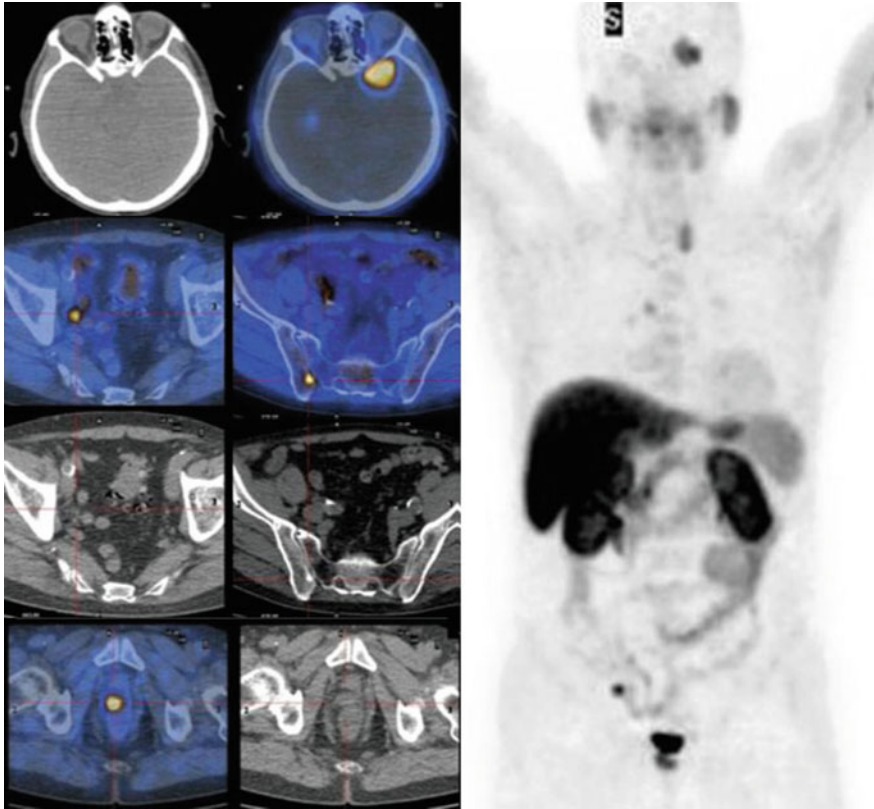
MIP image of ^{11}C -Choline PET/CT (right-sided panel of the figure), with transversal images of single pathologic findings in a high-risk PCa patient at initial staging; local recurrence (inferior view); imaging bone lesion and nodal involvement (mid views); a large malignant lesion is also visible in the brain (superior view)
